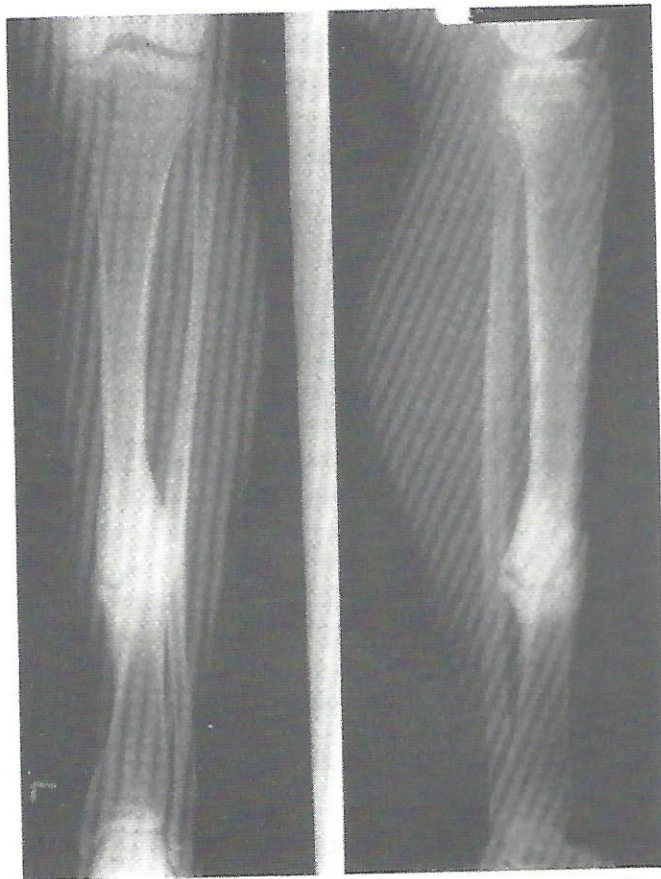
X-ray taken immediately prior to PEMF treatment in a 15-year-old female with a slightly comminuted fracture of the left distal tibia reveals insufficient deposition of periosteal callus and fibrous clouding of the gap nine months following injury.
